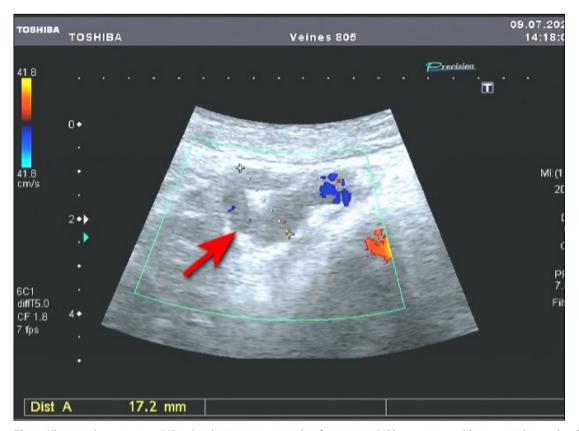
Ultrasound examination: IVC in the plication area 6 months after surgery: IVC lumen is intact (the arrow indicates the plication area with two formed channels)
